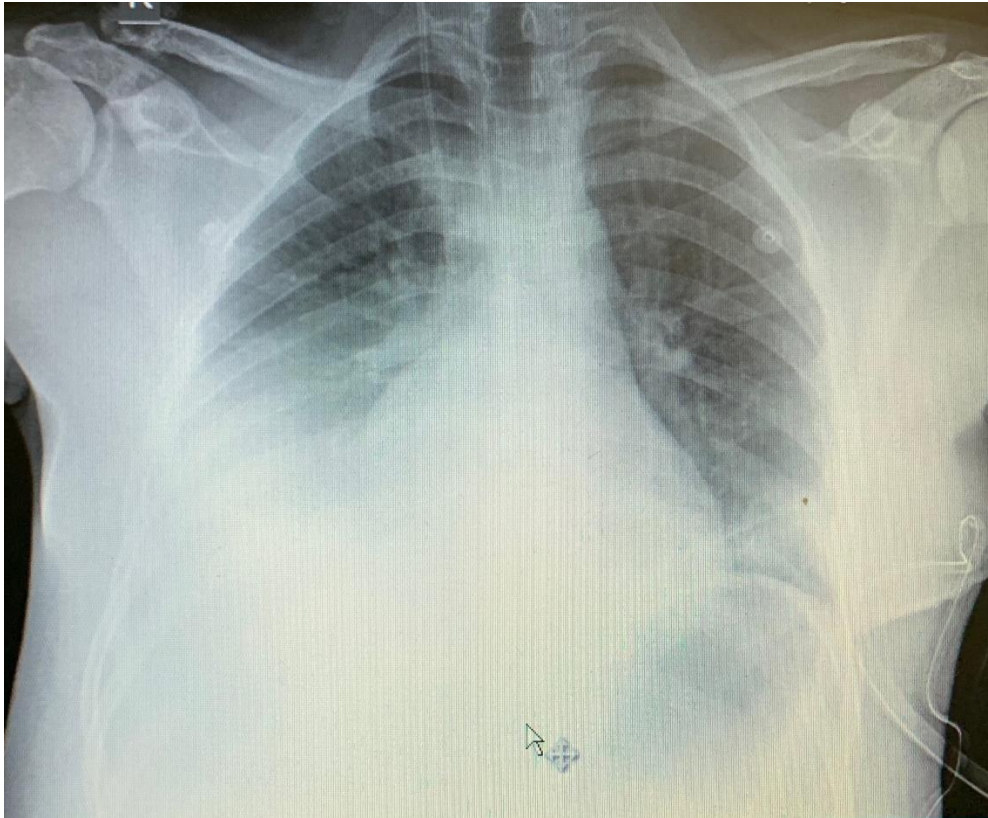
Case 3, chest X-ray before pleural puncture on the right side due to pleural effusion, third postoperative day
